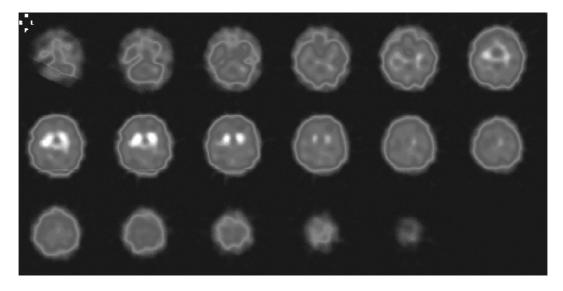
Second [123]]IBZM-SPECT investigation of patient no. 7 treated with 200 mg quetiapine. Striatum/occipital ratio: 1.57.
